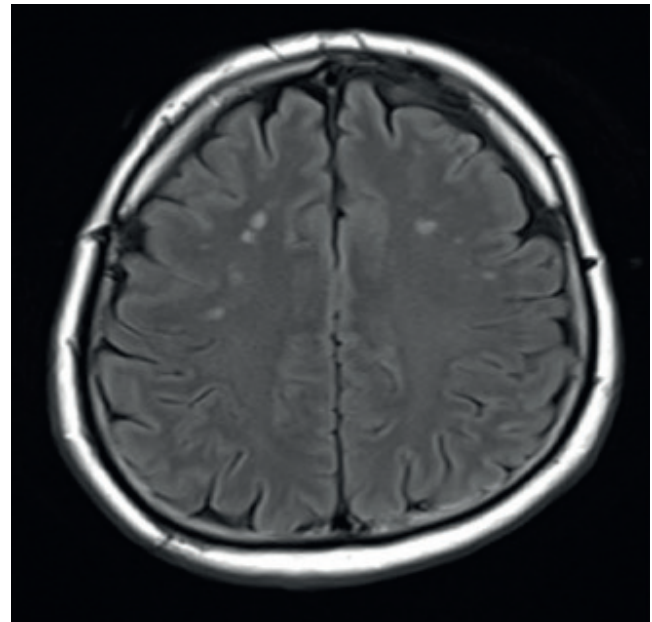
Gliotic foci with a tendency to coalesce in subcortical white matter in MRI
